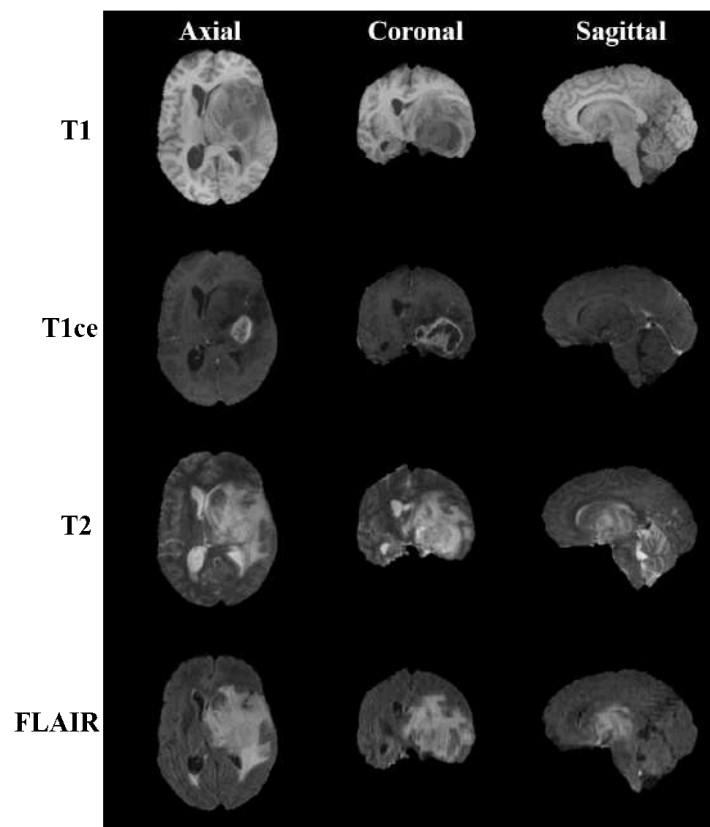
Different Multimodal MRI Scans- T1, T1CE, T2, T2-FLAIR
